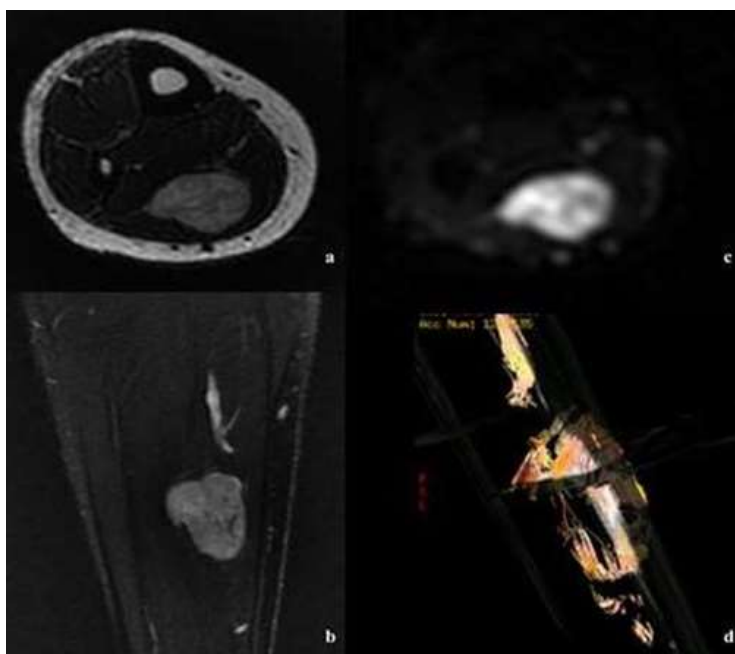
Axial (a) and coronal (b) MR images of a rounded fusiform lesion at the level of the posterior compartment of the leg (within the soleus muscle) showing intense, homogeneous contrast enhancement. Axial DTI sequence (c) with fiber track reconstruction (d) demonstrating it in another, the so-called anisotropy. In peripheral nerves, due to the presence of nerve fiber fascicles, water molecules tend to move in the direction of the axons (“anisotropic diffusion”). The differences in anisotropic characteristics of different tissues allow DTI to image nerve tracts and surrounding tissues. At our institution, we perform DTT using a 3 Tesla MRI scanner (EPI sequence, three diffusion directions, b value of 1000 s/mm²).
